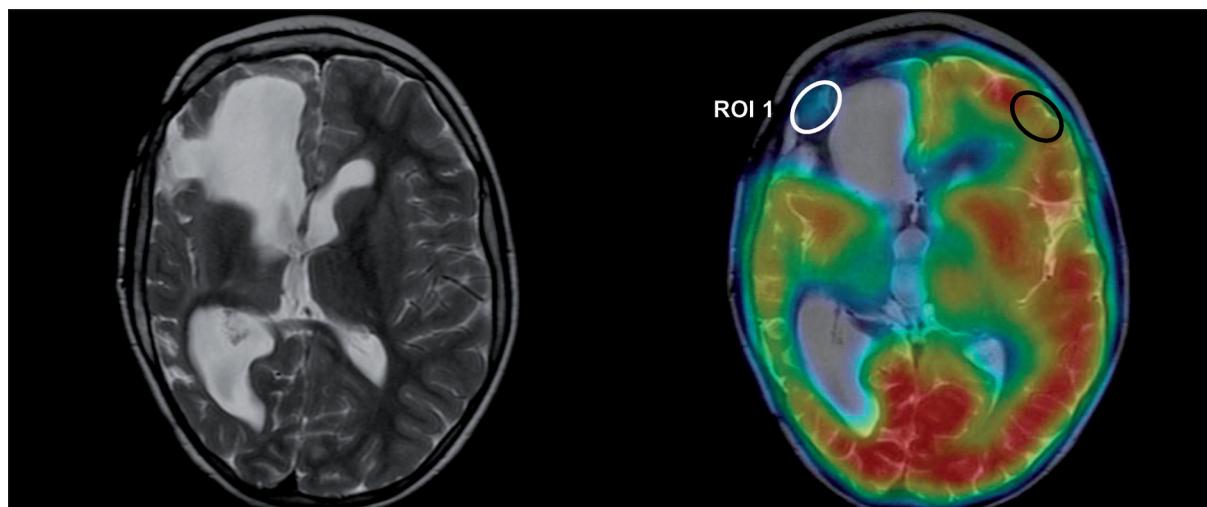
MRI image (A). Fusion of the MRI and SPECT image in the interictal phase (B) with a marked region of perfusion deficit within a fragment of the right frontal lobe, left after the previous surgical procedure (ROI 1 – white colour). A corresponding region in the frontal lobe of the left hemisphere, marked with black colour, revealing a normal perfusion in the SPECT examination.
